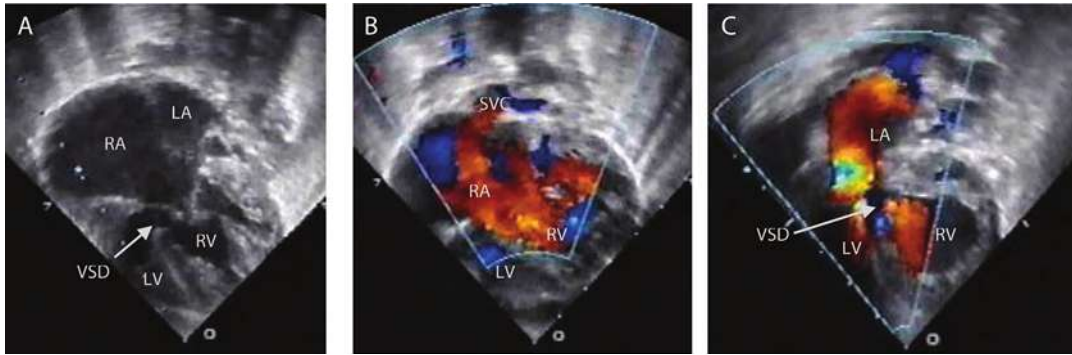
Subcostal 4 - chamber view in cases with situs solitus showed atrioventricular concordance connection with criss-cross atrioventricular relation: A. RA on the right side is connected to the rough trabecular RV on the left side, by color Doppler echocardiography the bloodstreams could be visualized: B. from superior vena cava (SVC) drained into RA - filled RV on the left side, C. LA on the left side filled LV on right side. RA – right atrium, LA – left atrium, SVC – superior vena cava, RV – right ventricle, LV – left ventricle, VSD – ventricular septal defect.
